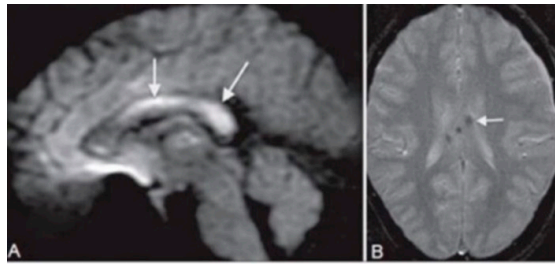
(A). MRI in sagittal view in ADC image shows the strong signal along the corpus callosum. (B) Axial MRI flair image showing a punctate hemorrhage in the corpus callosum. Source: Figure by authors.
